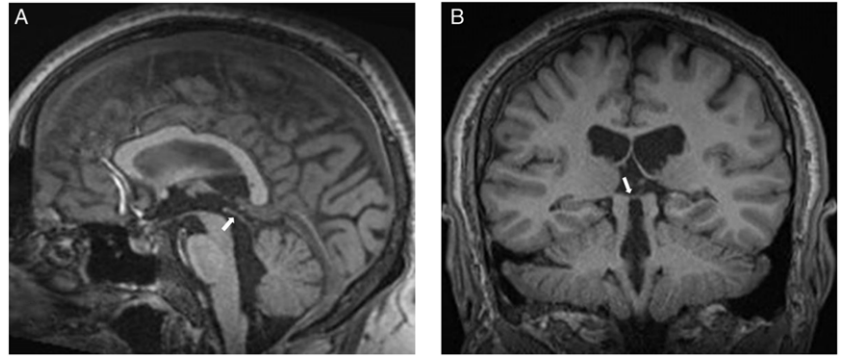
Midsagittal (A) and coronal at the level of the colliculi 3D MP RAGE (magnetization-prepared rapid gradient-echo imaging) (B) T1-weighted images (TR:1940, TE: 3.08) demonstrate thinning of the tectal plate/intercollicular commissure (arrows).
